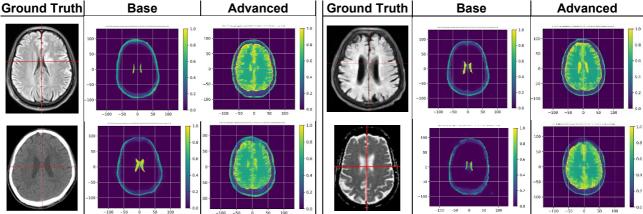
Four case studies from the probabilistic imaging model, presenting the ground-truth MRI or CT (left), base model (center) and advanced model (right)
